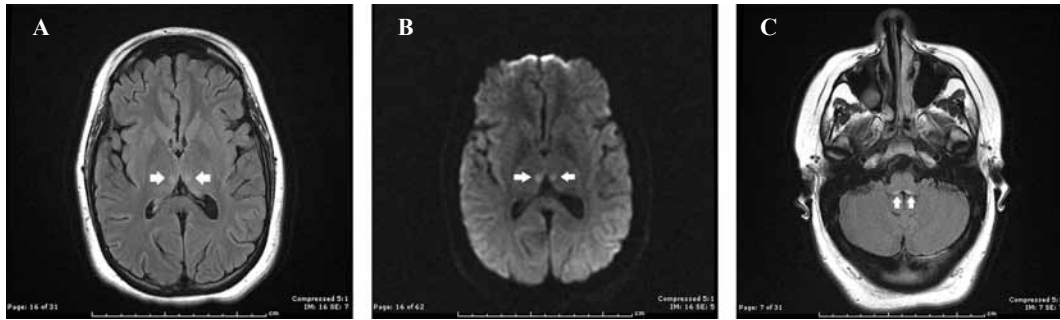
Symmetric findings on magnetic resonance imaging in Wernicke encephalopathy with arrows pointing toward the abnormalities. A: hyperintensities on T2 fluid attenuated inversion recovery sequence in the thalami; B: diffusion restriction in the thalami; C: hyperintensities along the posterior margins of medulla oblongata.
